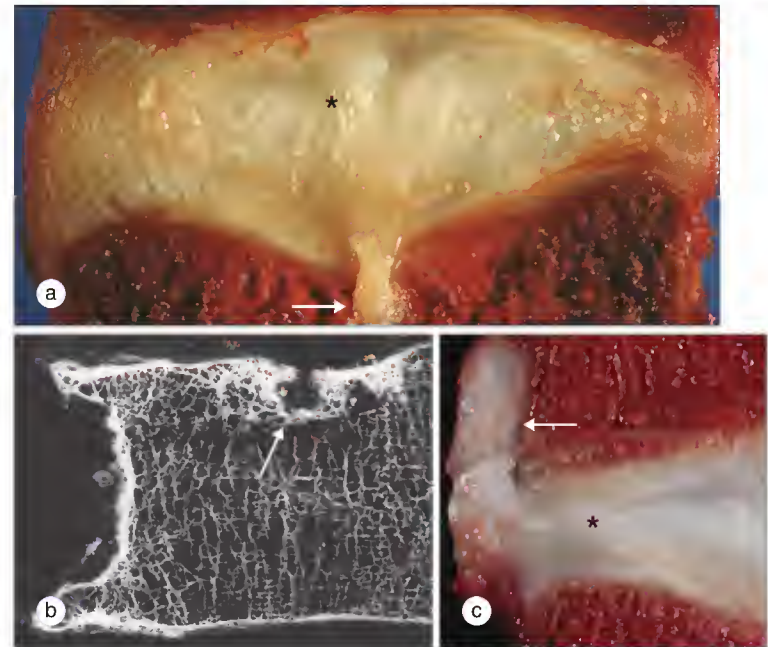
(a) Midsagittal section through a lumbar disk and vertebrae showing vertical herniation of the nucleus pulposus (arrow) as a result of compressive overload *in vitro*. In life, calcification around the herniation would create a Schmorl node. Note the inward collapse of the inner annulus (*). (b) Radiograph of a midsagittal section of a lumbar vertebra (anterior on the left). Note the large Schmorl node extending from the center of the upper endplate (arrow) and the large osteophytes on the anterior vertebral margins. (c) Compressive and bending overload *in vitro* can cause some nucleus pulposus (arrow) to herniate through a radial fissure in the posterior annulus (*). (Adapted from Adams MA, Bogduk N, Burton K, Dolan P. *The biomechanics of back pain*, 3rd ed. Edinburgh: Churchill Livingstone, 2013.)
